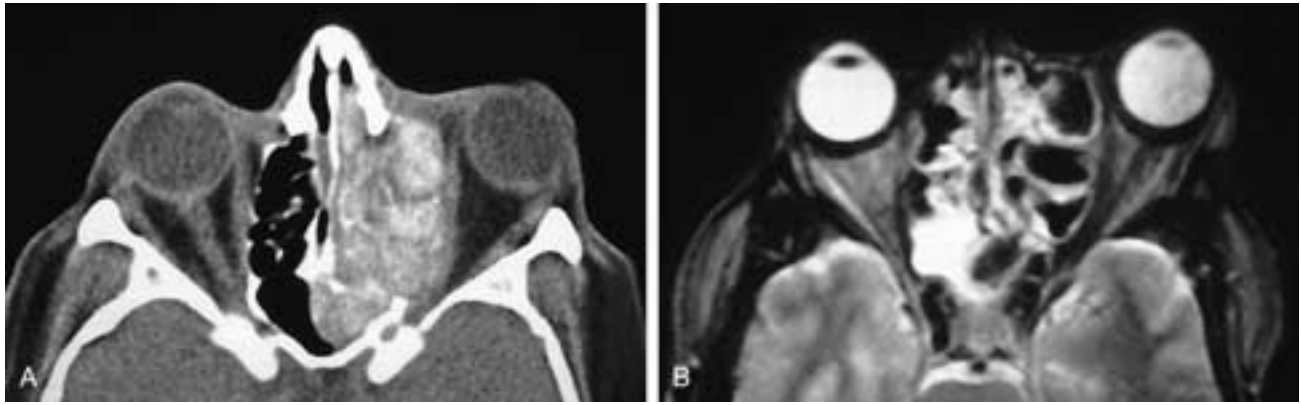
Axial CT scan (A) shows a mass in the left ethmoid and sphenoid sinuses that has broken out into the left orbit. There are discrete areas of high attenuation. The localized areas of high density on this non-contrast CT makes an inflammatory process likely, but not definite. However in B, a T2-weighted MR image, the areas of high attenuation in A have signal voids. This indicates that they are most likely either desiccated secretions or mycetomas. This patient had aspergillosis.
